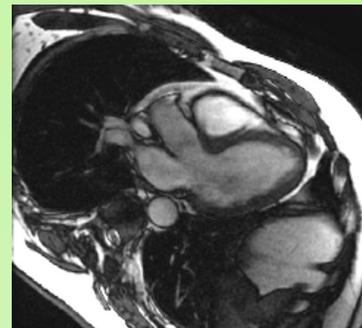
Cardiac MRI with no evidence of myocarditis or sarcoidosis.
